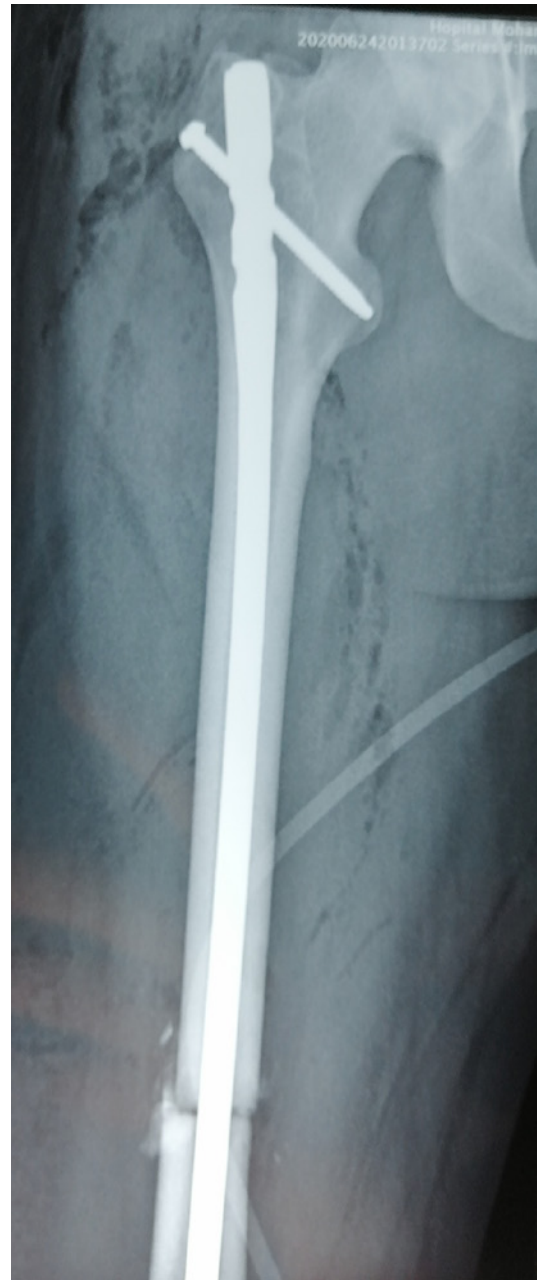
Standard X-ray imaging of the right thigh after closed intramedullary nailing.
